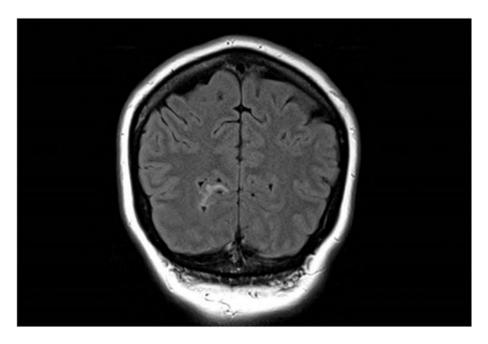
Coronal FLAIR MRI sequence showing a hyperintense lesion in the primary visual area.
